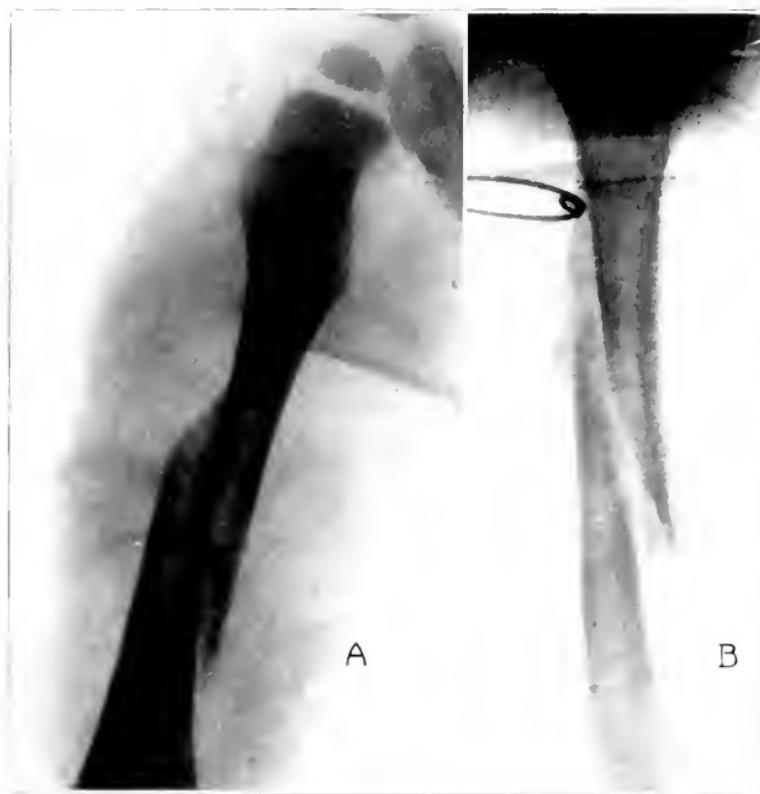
A*, oblique fracture of middle third of femur of patient, 2 years of age; roentgenogram taken at time of fracture; *B*, appearance of femur two weeks after fracture and application of overhead traction.
